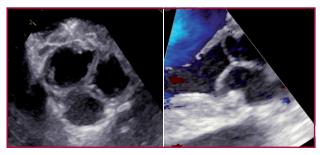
Transesophageal echocardiography shows adequate cusp coaptation without aortic regurgitation.
